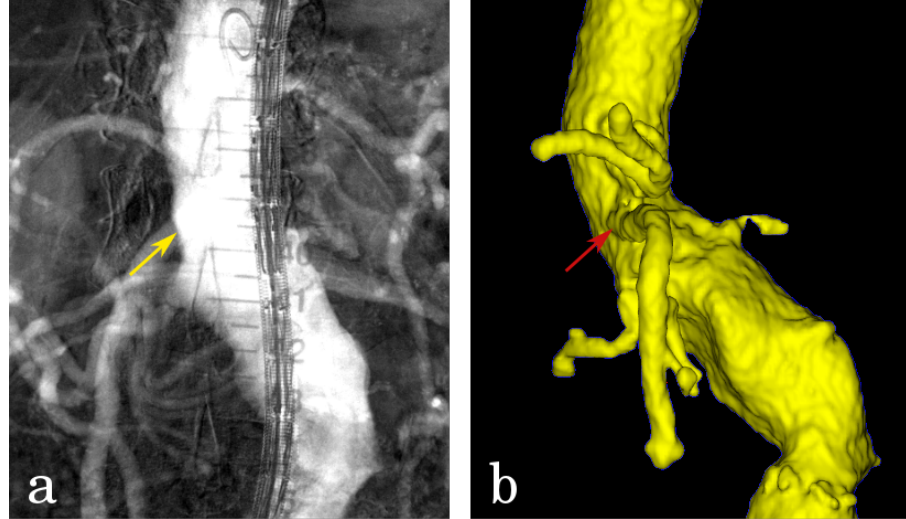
An example of vasculature overlap in the produced DSA image. a) A DSA image of the aorta produced from \sim AP view, and b) a CT surface rendering of the aorta also produced from \sim AP view. The vessel's ostium indicated by the red arrow in 'b' is inaccurately identified in 'a' (yellow arrow) because it is obscured by the aorta.
